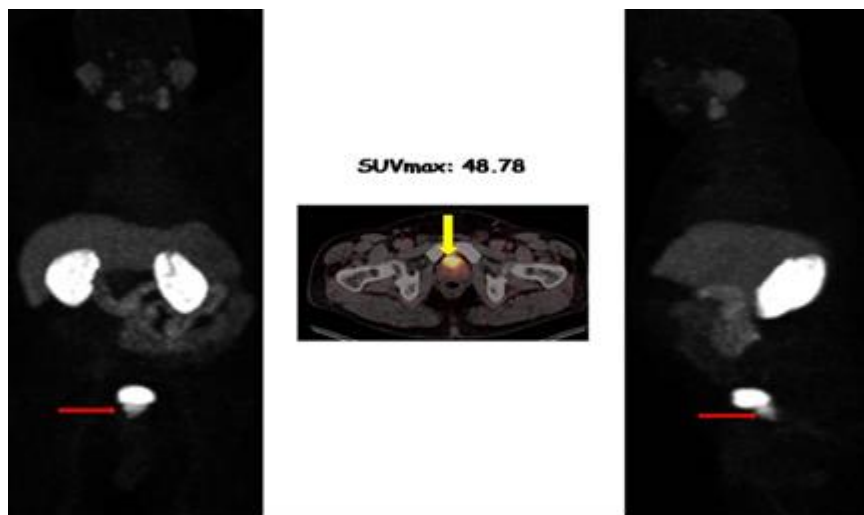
Coronal and sagittal MIP (Maximum Intensity Projection Image) and axial PET-CT fusion images in 60 years of newly diagnosed prostate cancer patients. Gleason score 10 (5+5), prognostic grade 5 and perineural invasion were detected on pathological examination. The patient with PSA level 39, underwent Ga-68 PSMA imaging for initial staging because of suspected metastases. On Ga-68 PSMA PET/CT imaging hypermetabolic (SUVmax: 48) 3.5X3 cm primary prostate mass was detected. There was any other metastatic region despite the high PSA level. After radical prostatectomy and lymph node dissection all lymph nodes were reactive in accordance with Ga-68 PSMA PET/CT results.
